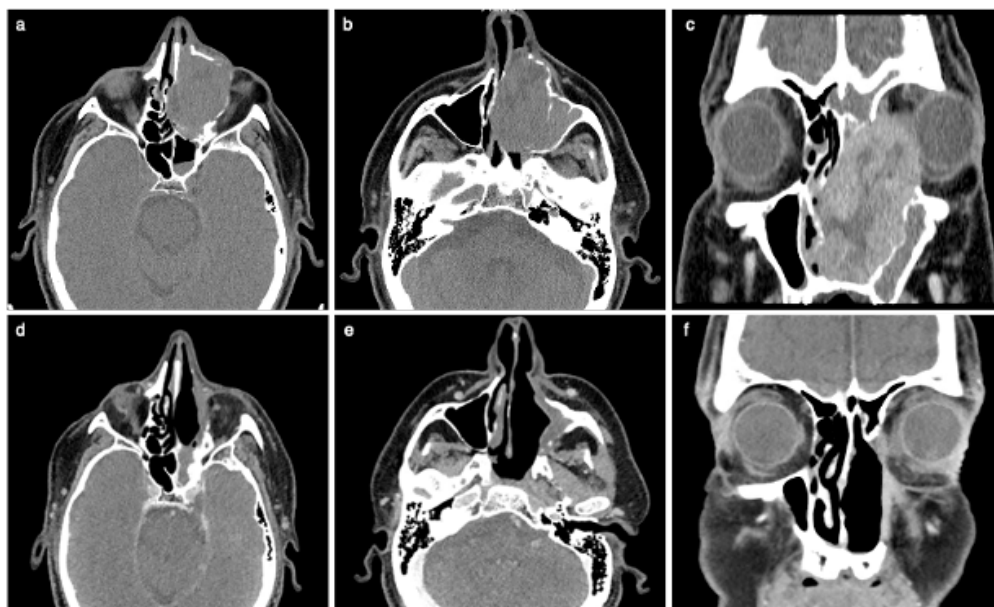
Preoperative (a,b,c) and postoperative (d,e,f) CT images are shown in axial (a,b,d,e) and coronal (c,f) slices of the patient
